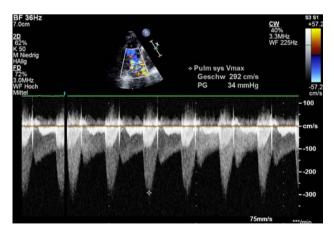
CW Doppler of the left pulmonary artery after bilateral pulmonary artery banding with a peak gradient of 35 mm Hg. Systemic blood pressure was 55 mm Hg
